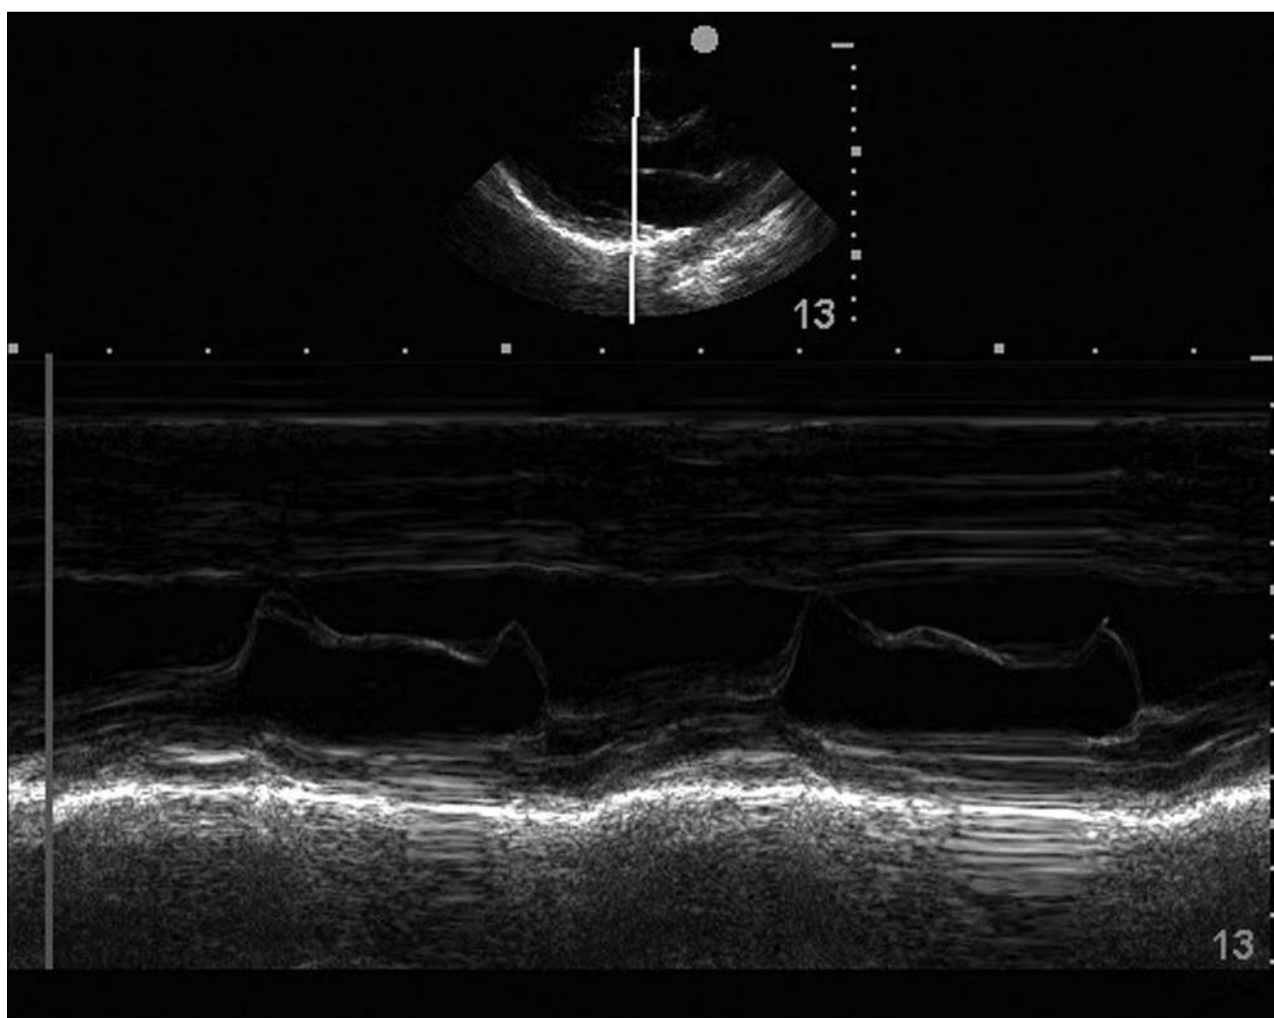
Parasternal long-axis M-mode view, normal ejection fraction, normal E-point septal separation (EPSS). Parasternal long-axis M-mode view with M-mode with marker across the anterior mitral valve (MV) leaflet, with the movement of the anterior MV leaflet plotted versus time. The first peak in its excursion represents the E point; it corresponds to MV inflow secondary to ventricular relaxation. The second peak, the A point, is secondary to MV inflow from atrial contraction. Note the normal EPSS within the normal range of < 0.85 cm.
